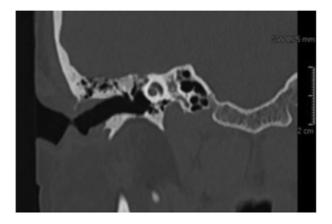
Coronal computed tomography scan showing the osteoma arising from the malleus head.
